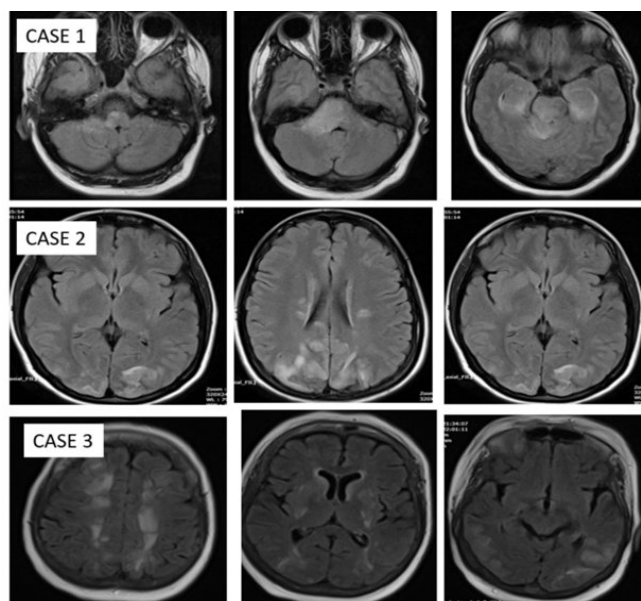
Showing MRI brain axial sequences showing hyperintensity in brainstem and temporal lobe (central PRES) in case 1, and hyperintensity in T2 flair in subcortical parieto-occipital region (classical PRES) in case 2 and case 3.
